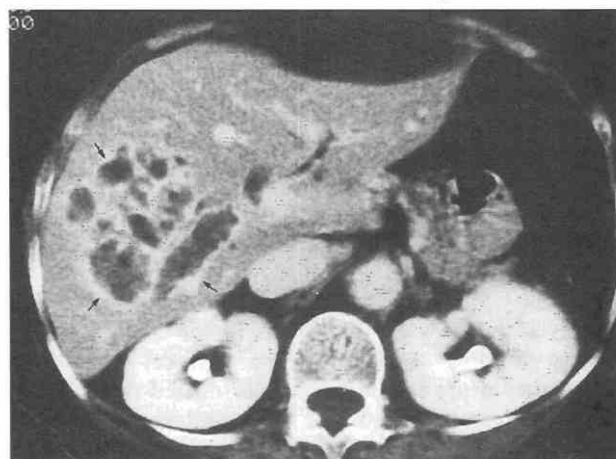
Acute exacerbation of recurrent pyogenic cholangitis with dilated right intrahepatic bile ducts and periductal enhancement (arrows). (From Chan F, Man SW, Leong LL, Fan ST: Evaluation of recurrent pyogenic cholangitis with CT: Analysis of 50 patients. *Radiology* 170:165, 1989.)
